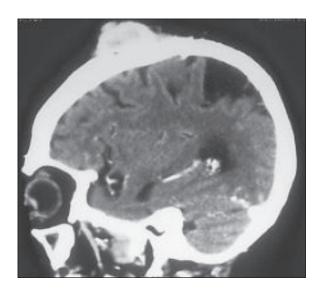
Post operative contrast CT scan showing flare up of preexisting smaller skin nodule.
